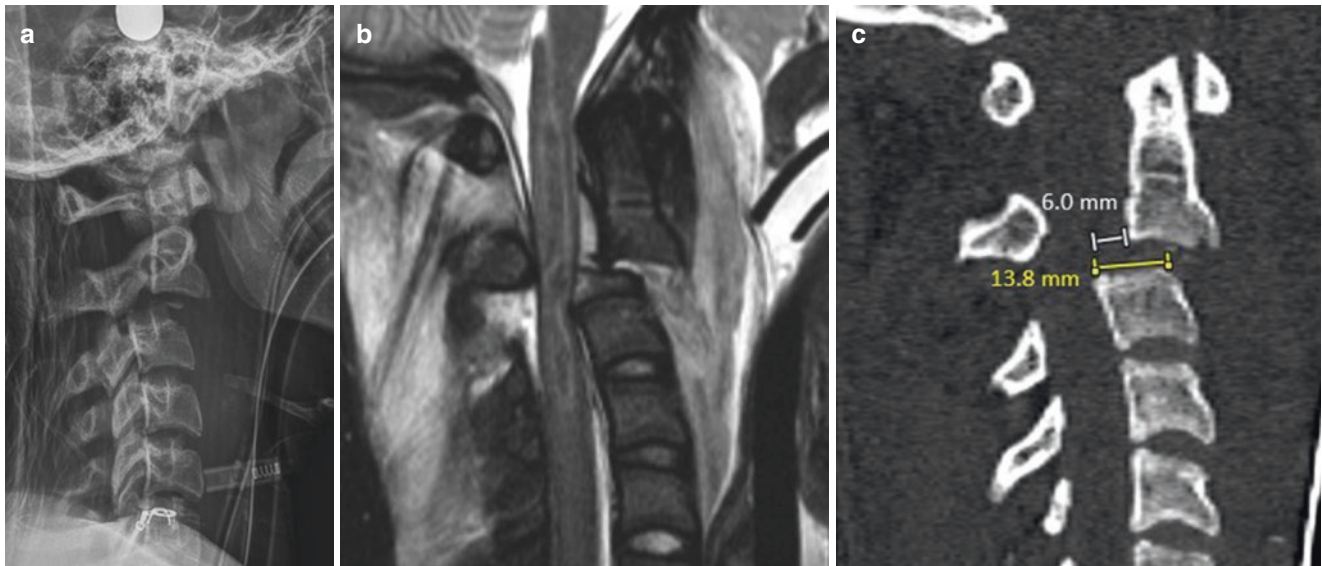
An 18-year-old man who was a restrained passenger in a motor vehicle accident, where his car collided with another vehicle and rolled into a ditch. Unfortunately, the patient did not survive the accident and passed away several days later. (a) Lateral radiograph demonstrates anterolisthesis of the widened C2–C3 disk space, comminuted fracture fragments in the disk space, probably from the C3 superior endplate, and bilateral perched facets. (b) Sagittal T2 fat-suppressed image through the midline of the upper cervical spine demonstrates complete separation of the C2 inferior endplate from the C2–C3 intervertebral disk, anterior longitudinal and posterior longitudinal ligament injury, and interspinous ligament injuries. There is extensive anterior and posterior soft tissue hemorrhage. There is also hemorrhage within
